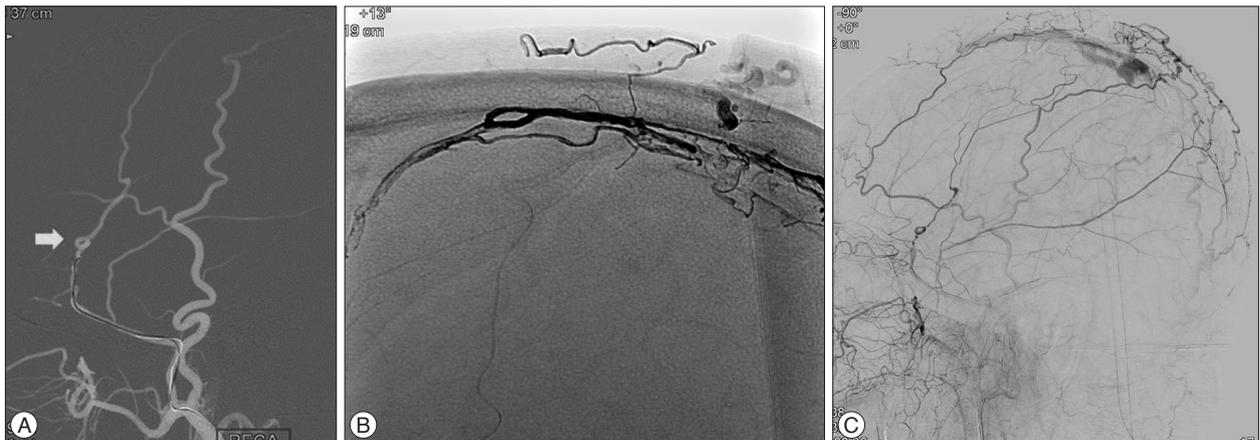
Radiologic images obtained during first embolization session. Lateral view of roadmap image showing the tortuous turning point (arrow) beyond the foramen spinosum level (A). Postoperative skull radiographs showing the Onyx cast after incomplete embolization (B). Postoperative angiogram showing the incomplete obliteration of dAVFs (C). dAVFs : dural arteriovenous fistulas.
